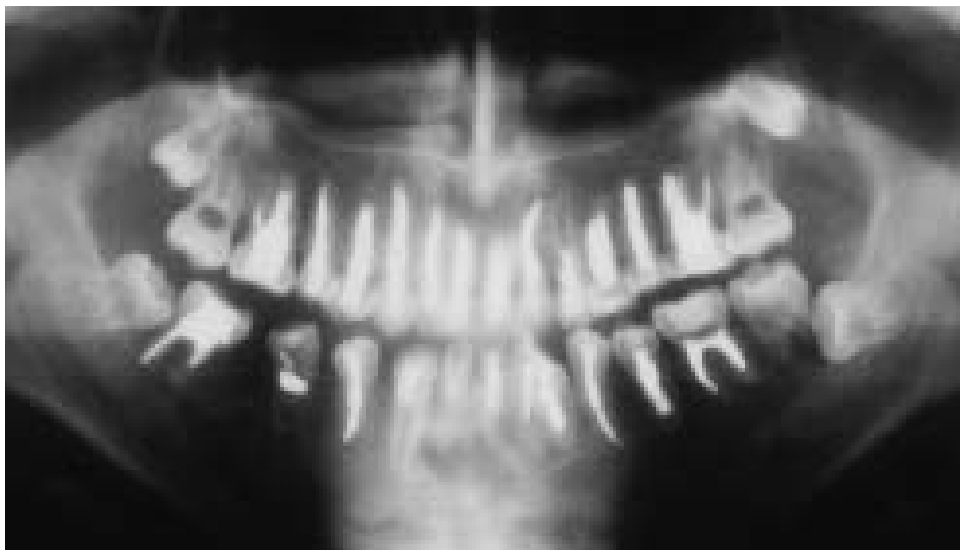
Orthopantomogram 2 years after canal treatments.
